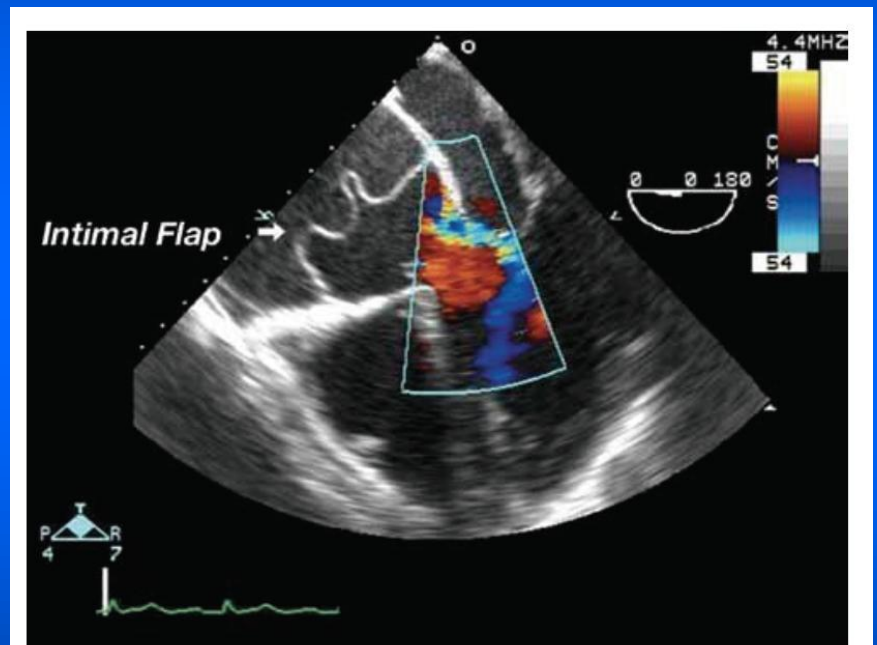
Transesophageal echocardiography mid-esophageal four-chamber view (zooming on the aortic valve), showing acute aortic dissection with an intimal flap (arrow). Color Doppler shows severe aortic regurgitation.
